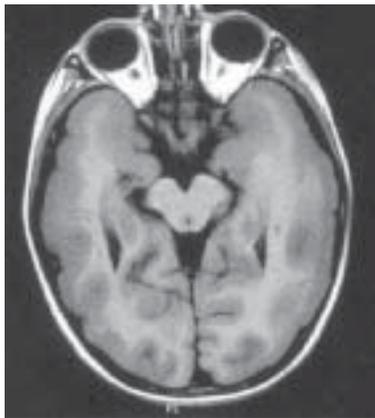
MRI scan of the brain of a child with mental retardation and seizures showing broad and thick gyri—pachygyria.
